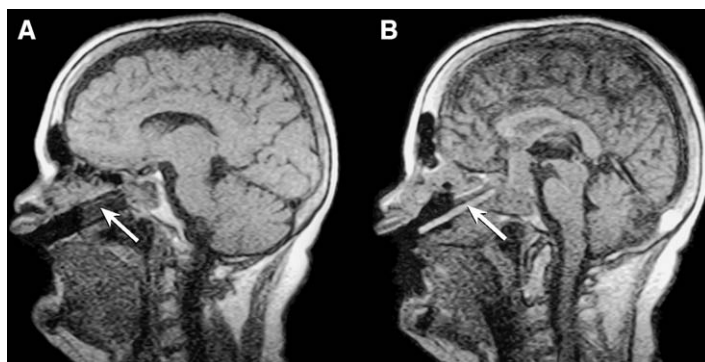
Intraoperative MRI was occasionally used to verify the trajectory to the floor of the sella before its exposure. (A) Sagittal midline image with a cylinder-shaped signal void from the titanium speculum pointing at the sella (arrow). (B) An alternative localization technique using a tuberculin syringe filled with gadolinium (arrow). (Courtesy of the Mayfield Clinic, Cincinnati, OH.)
